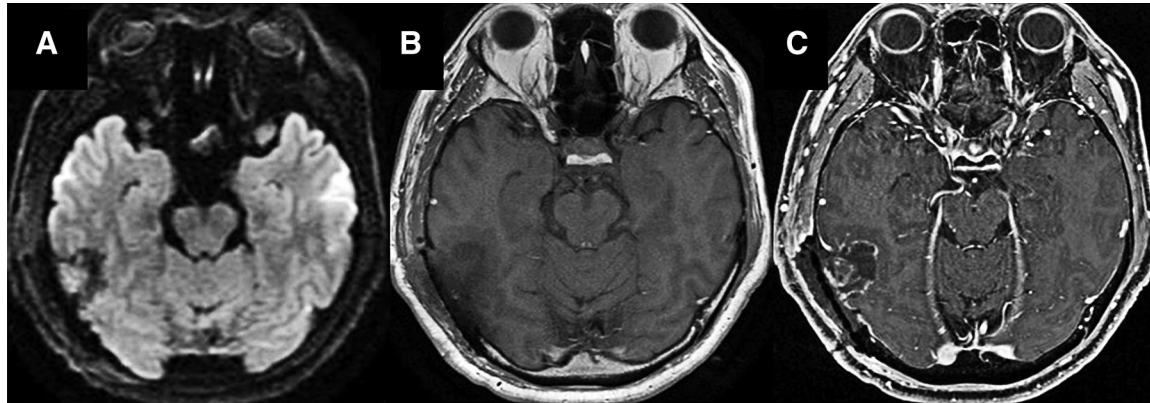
Postoperative MRI showing total resection of the tumor. (A) DWI. (B) T1. (C) T1Gd(+).
